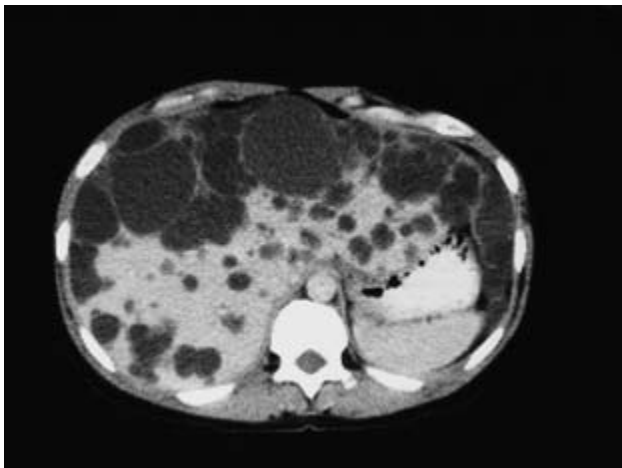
CT scan (contrast enhanced) showing a polycystic liver.
